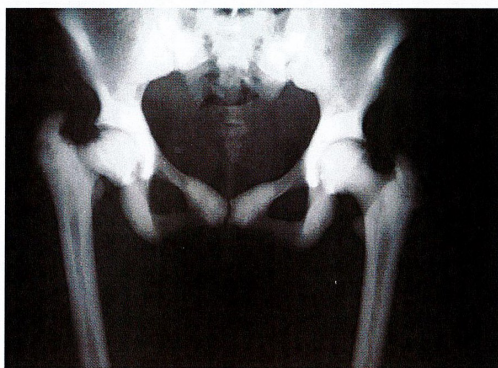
Radiographic findings showing diffused bilateral narrowing of the intramedullary canals. Blastic activity involving the iliac bones and the sacral ala is also observable. Patient demonstrates right femoral neck fracture with varus deformity.
